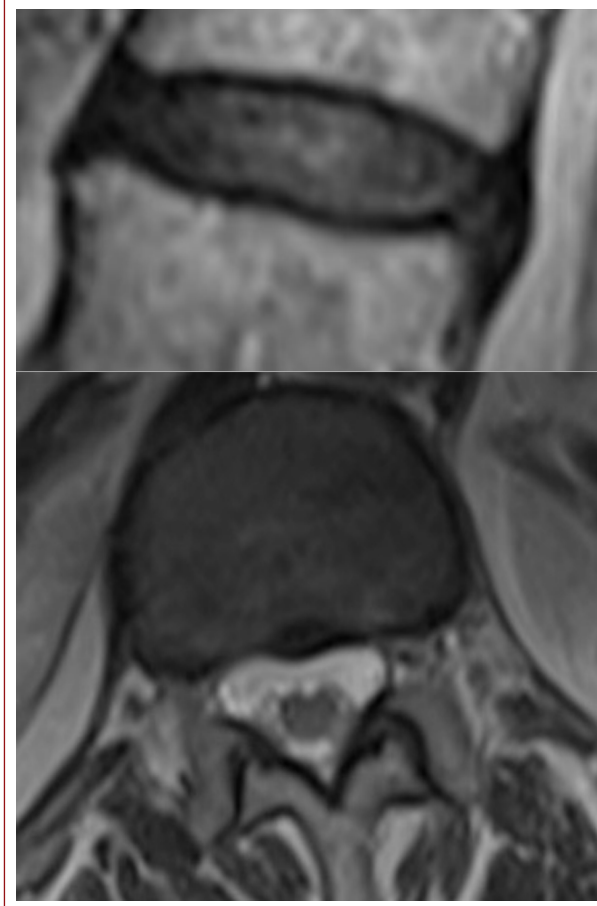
a) Grade 3 degeneration of T12–L1 disc of a 76-year-old female patient in a T2-weighted sagittal image, b) in axial image, focal minimal disc protrusion is seen with diffuse annular bulging at the same level.
